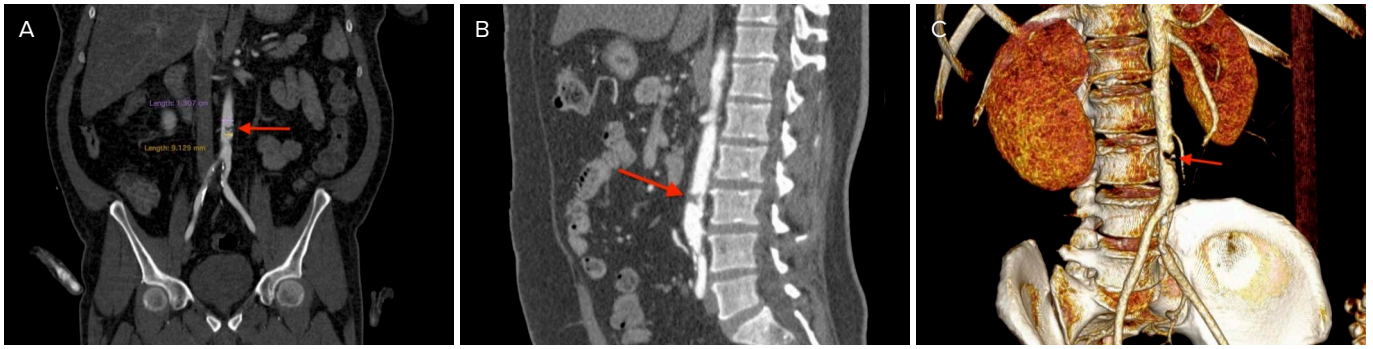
A – CT angiography coronal section, showing severe stenosis of the abdominal aorta; B – sagittal section showing the stenosis; C – 3D reconstruction showing severe isolated stenosis and subsequent repermeabilization without distal stenosis
